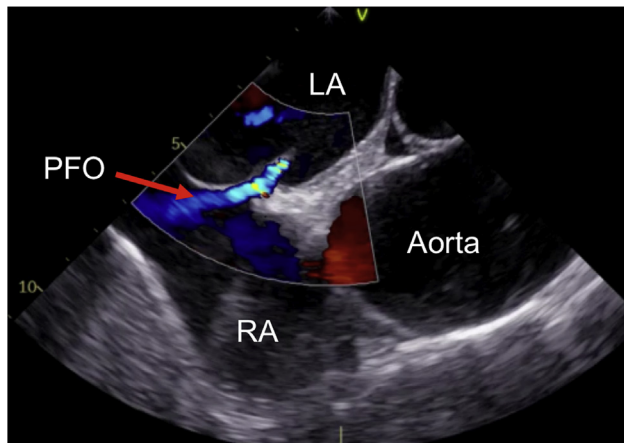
Transesophageal echocardiogram of a patient with patent foramen ovale that is crossed with a 0.035-inch guidewire. Communication between the right and the left atrium is depicted by color-flow Doppler. LA: left atrium; PFO: patent foramen ovale; RA: right atrium.
